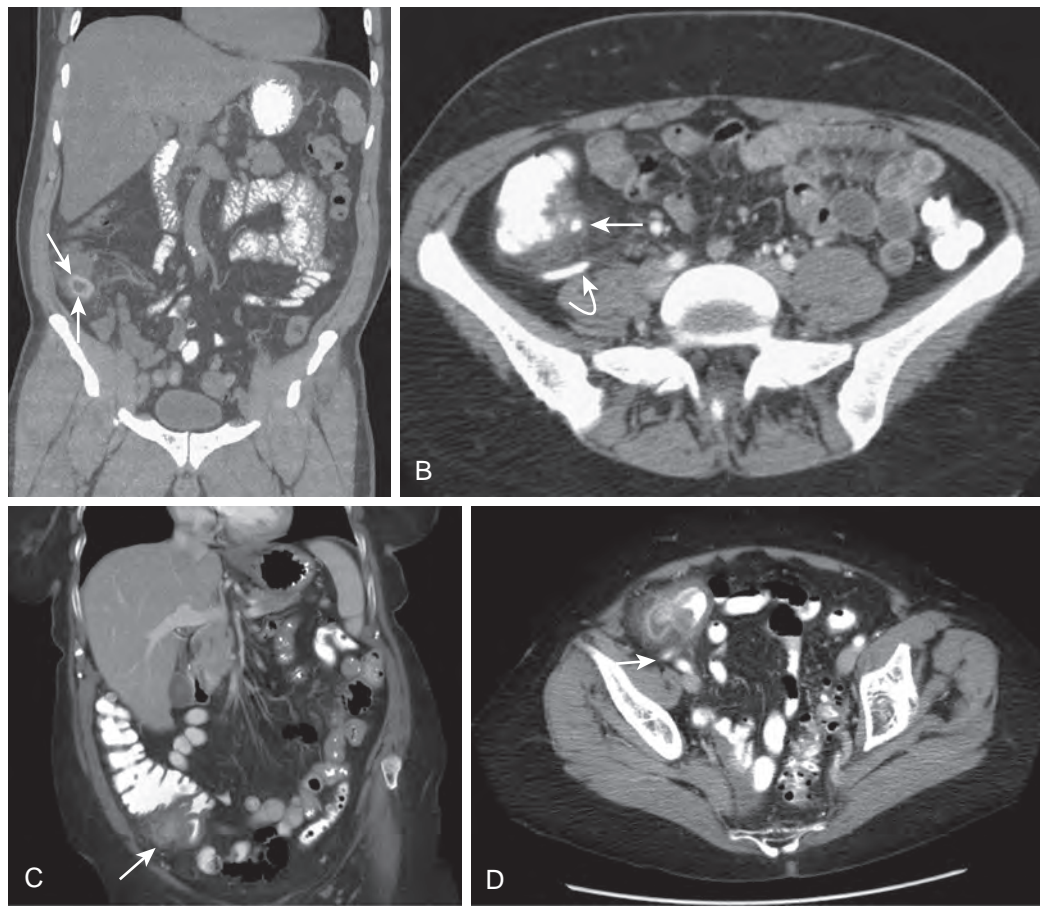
Right-sided diverticulitis: imaging considerations. A. Coronal reformatted image shows the hyperdense offending diverticulum (arrows) associated with considerable inflammatory change in the adjacent fat. B. Axial scan of different patient shows contrast filling a normal appendix (curved arrow) and the offending diverticulum (straight arrow). C. Postcontrast coronal reformatted CT image demonstrates focal pericolic inflammatory changes, with wall thickening and suggestion of the inflamed diverticulum (arrow). D. Note the contrast-filled posterior to the cecum on the axial image (arrow).
